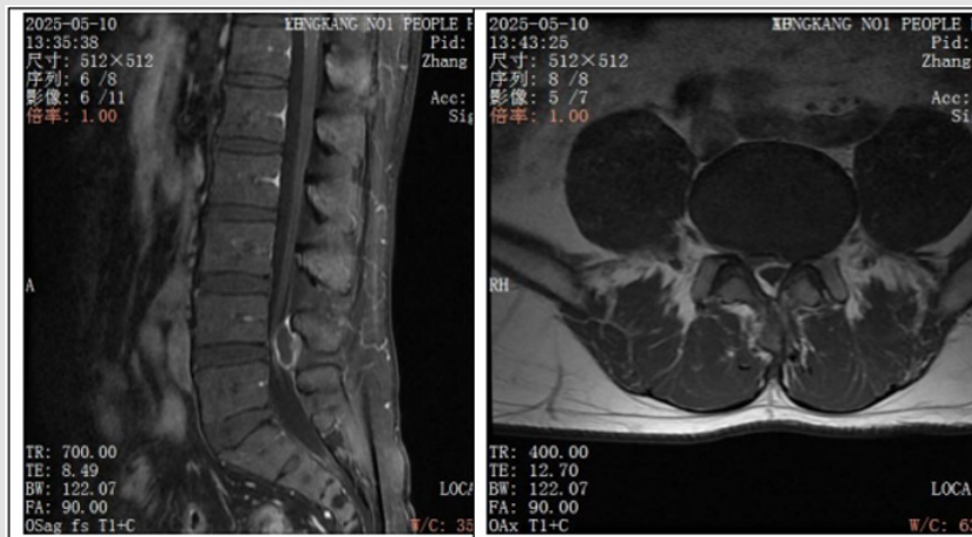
MRI images of preoperative free dorsal epidural herniation at L4-L5.
